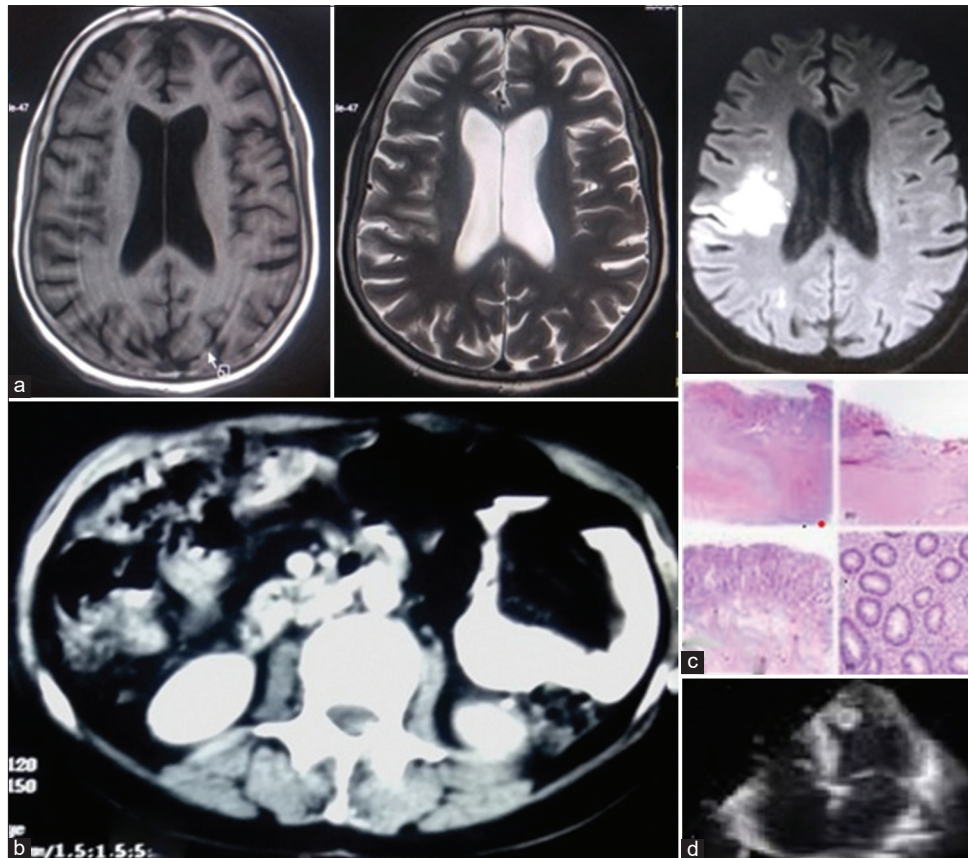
(a) Images of MRI brain of the patient with T1, T2, and DWI sequences. DWI showing acute infarct in right middle cerebral artery territory; (b) Images of Contrast CT Abdomen showing thick edematous bowel loops; (c) Transmural involvement, noncaseating, non-confluent granulomas, deep fissuring into muscularis propria with strictures, cryptitis, and crypt abscess, serosal vascular congestion; (d) 2D-Echo showing clot in left ventricle
